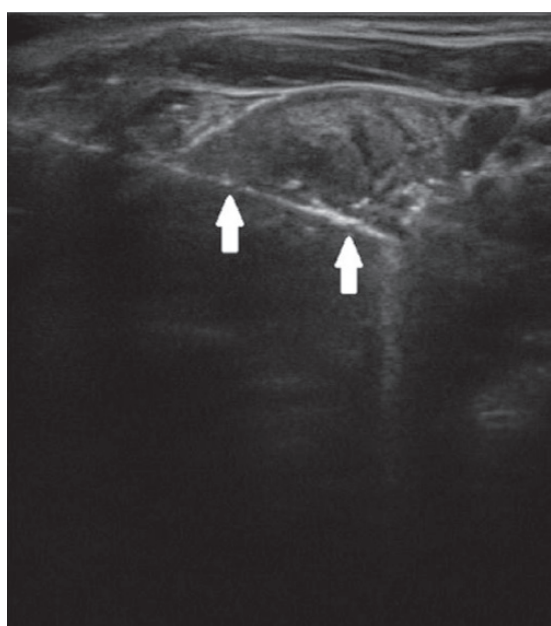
Sonographical imaging of the thyroid during ablation. Note how the microwave probe, white arrows marking its position, is completely visualized in order to ensure its correct placement and to avoid damage of adjacent structures.
